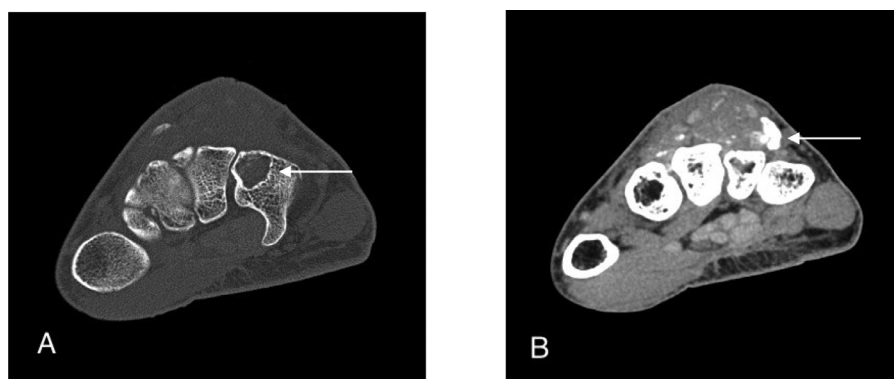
(A) – Noncontrast axial CT image of the wrist shows a lucent lesion (white arrow) within the dorsal aspect of the hamate with a dorsal soft tissue mass. (B) Axial CT image of the wrist slightly distal to the level of A in soft tissue window demonstrates the mass (white arrow) to a better advantage with visualization of internal calcifications.
